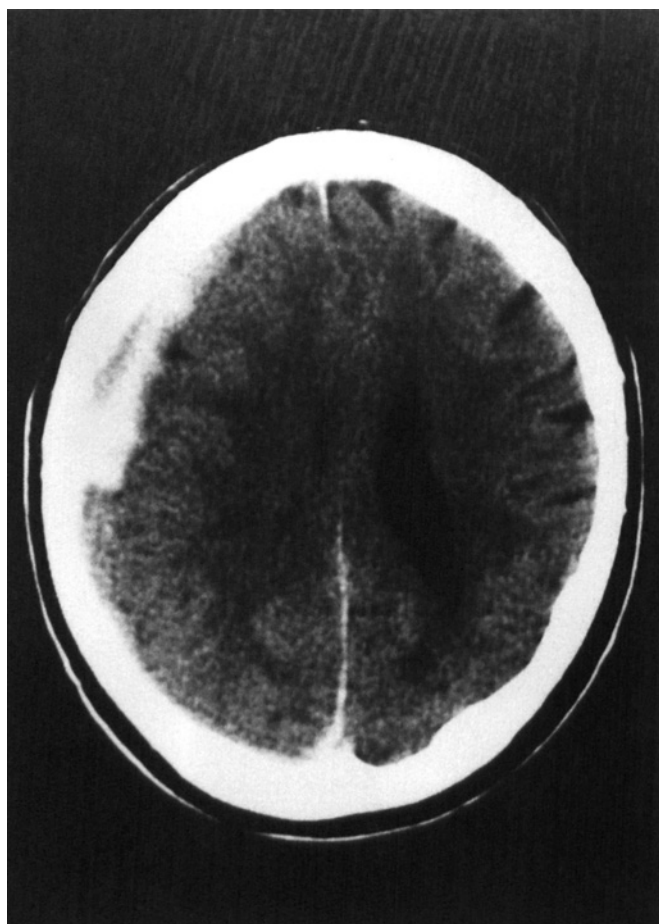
Cranial CT of the skull showing right-sided subdural haematoma with compression of the right ventricle.
